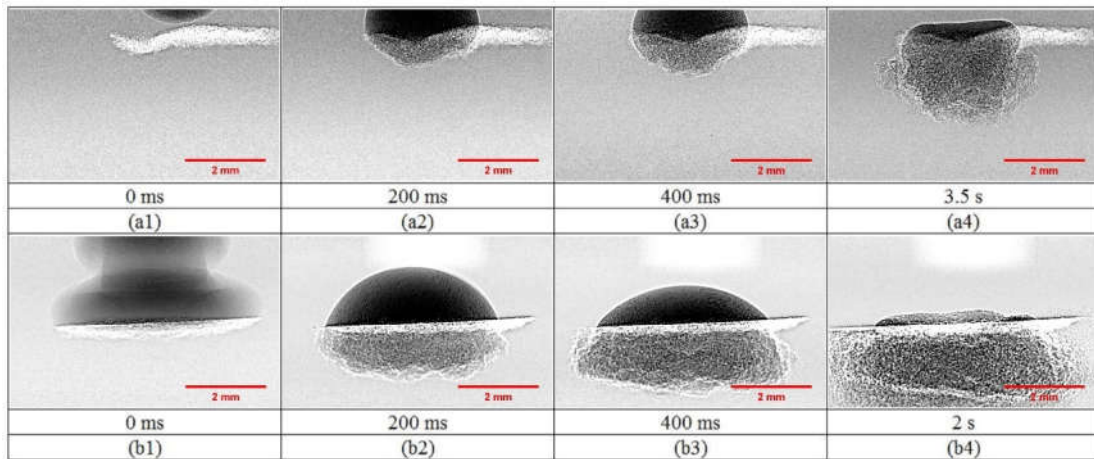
The time sequence X-ray images of the granulation process of LMH powder with water as a liquid binder released from 2.5 cm at volumes of (a1-a4) 10 μl and (b1-b4) 15 μl .
